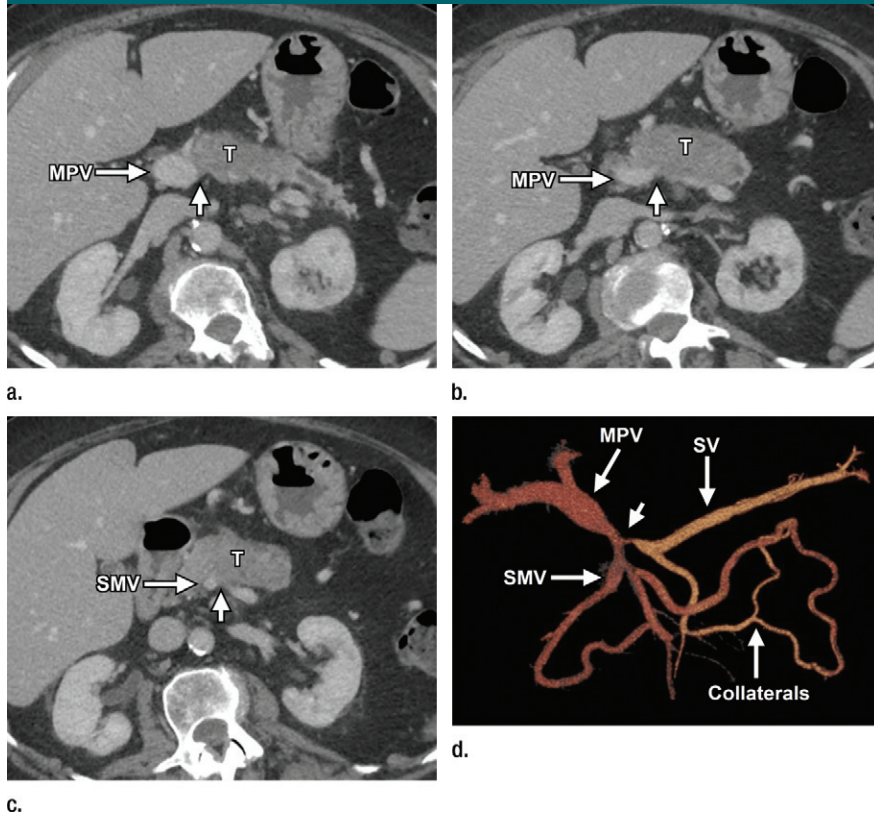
Three-dimensional volume rendered display of multivessel tumor involvement. (a–c) Axial contrast-enhanced biphasic multidetector CT angiograms demonstrate a mass in the body of the pancreas (T) with more than 180° of contact with the MPV, splenic vein, and SMV and narrowing of the vessels (short arrow). (d) The multifocal narrowing and the length of tumor contact, as well as the presence of collaterals, are better delineated on the three-dimensional volume rendered display (short arrow). This degree of tumor contact with the MPV and SMV places the patient in the borderline resectable category. SV = splenic vein.
